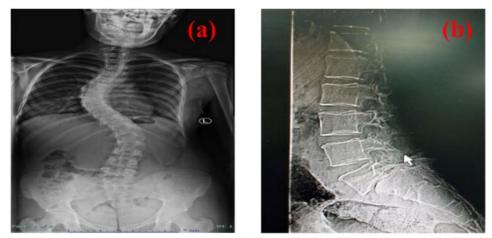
X-ray images in dataset (a) scoliosis, (b) spondylolisthesis
